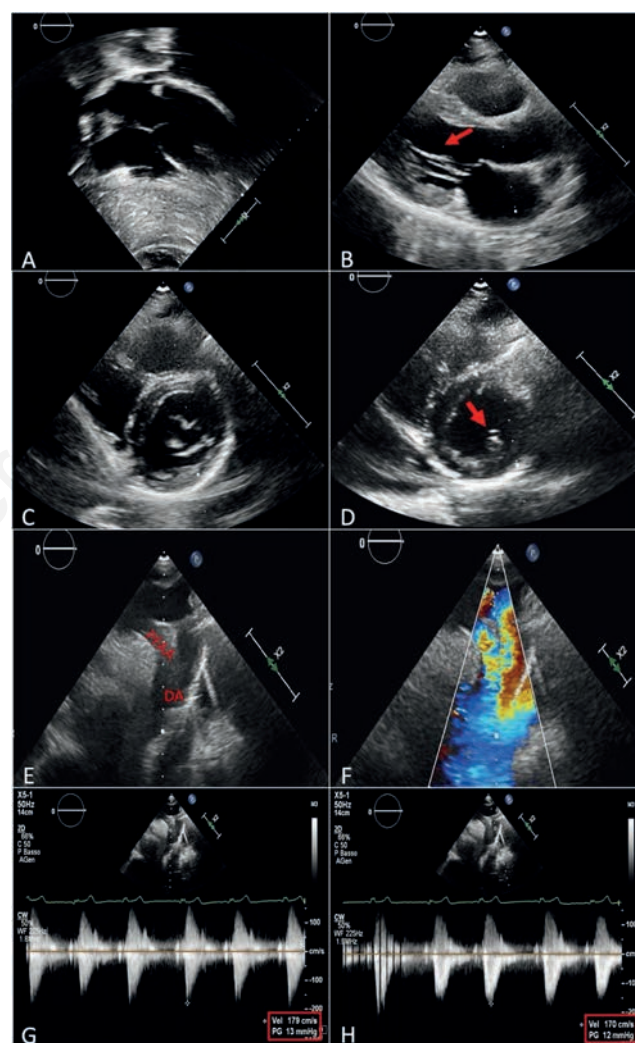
A) Subxiphoid long-axis view showing situs solitus and levocardia; B) at parasternal long-axis view, single papillary muscle was detected (red arrow); C,D) short axis view showing cleft of anterior mitral leaflet and single papillary muscle (red arrow); E) suprasternal views showing Freedom type 1 PFAA; F) color doppler flow imaging shows the “double-lumen aortic arch”, in which aortic arch is divided into the superior and inferior channel. The lower arch is a persistent fifth aortic arch (PFAA) that arises from the ascending aorta and is parallel with the fourth arch (aortic arch); the fourth arch and PFAA connect to the descending aorta together; G,H) continuous wave Doppler showed non-significant peak gradient of 13 and 12 mmHg on PFAA and fourth arch, respectively.
